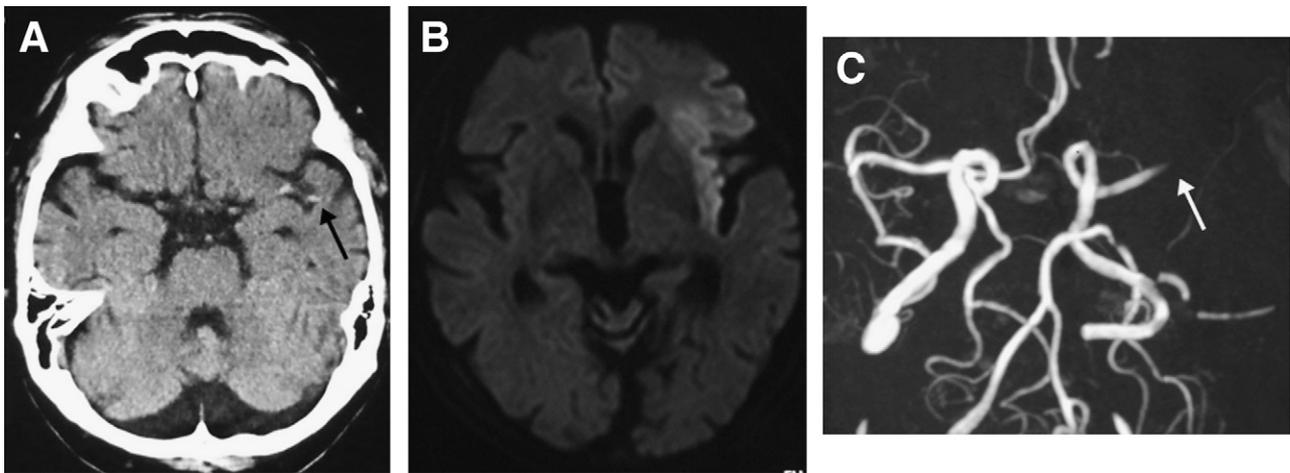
(A) CT scan obtained on admission showing HMCAS of the left MCA. A small hyperdense nodule on the left MCA might retrospectively implies a possible cerebral aneurysm (arrow). Neither hemorrhage nor massive early signs of infarction were apparent. (B) Diffusion-weighted MRI image obtained on admission showing an ischemic area of the left frontal lobe and the left insular cortex. (C) MRA obtained on admission demonstrating an obstruction of the sphenoidal segment of the left MCA (arrow).
